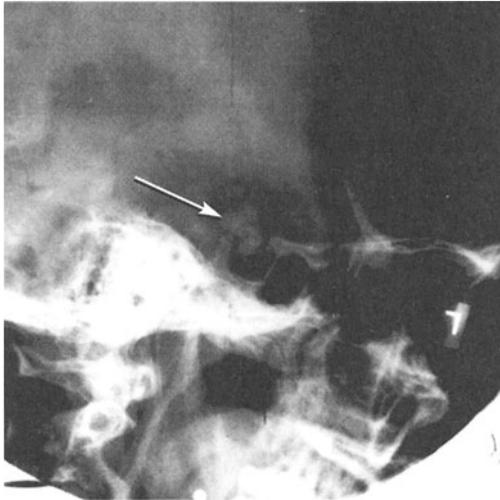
Skull X-ray Suprasellar Tumor: Craniopharyngioma. Enlarged sella turcica, and suprasellar calcification with changes in the anterior and posterior bony components (clinoids). This 23-year-old female had a six-year history of intermittent headaches and amenorrhea and recent diplopia. She had bilateral papilledema and an elevated serum prolactin level. Refer to figure 2-13 (A) for a normal comparison (see also figure 27-14 for a CT scan of this case).
